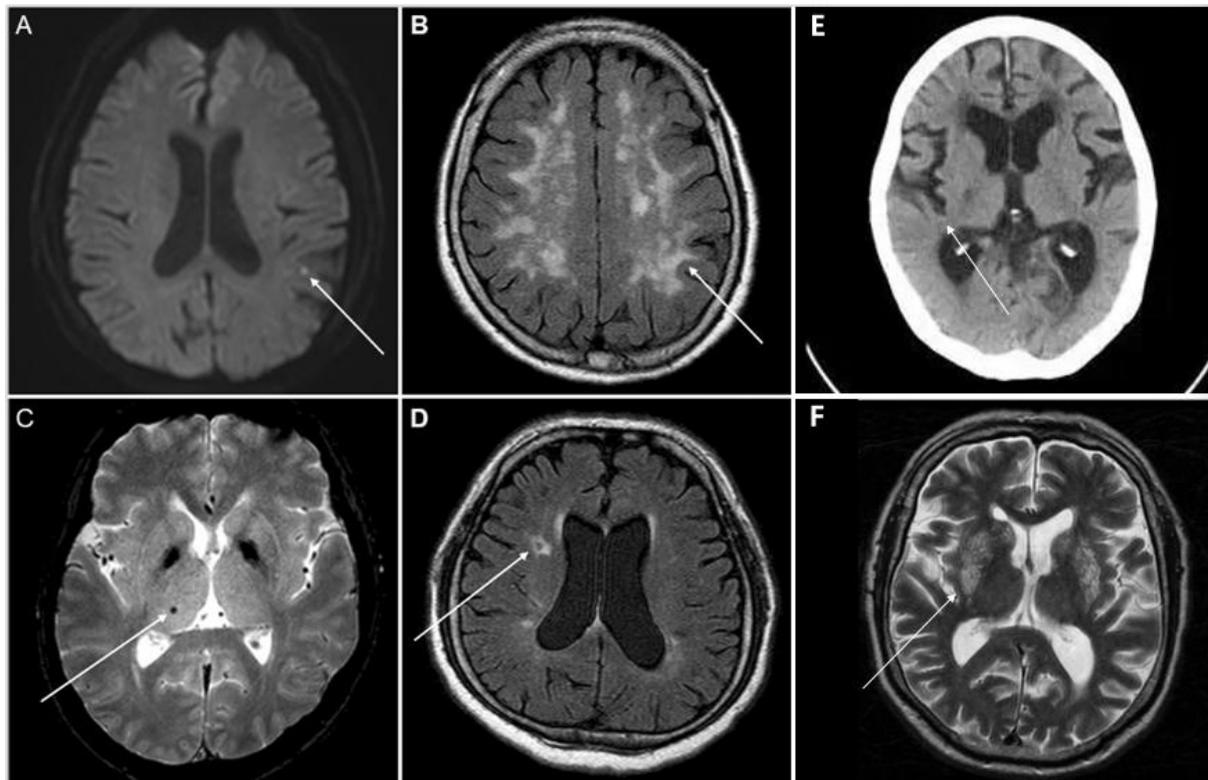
Several classifications of cerebral Small Vessel Disease (CSVD) on MRI images, A: subcortical infarction, B: White Matter Hyperintensity (WMH), C: cerebral microhemorrhage, D: lacunar infarction, E: brain atrophy, F: Enlarged Perivascular Space (ePVS).
